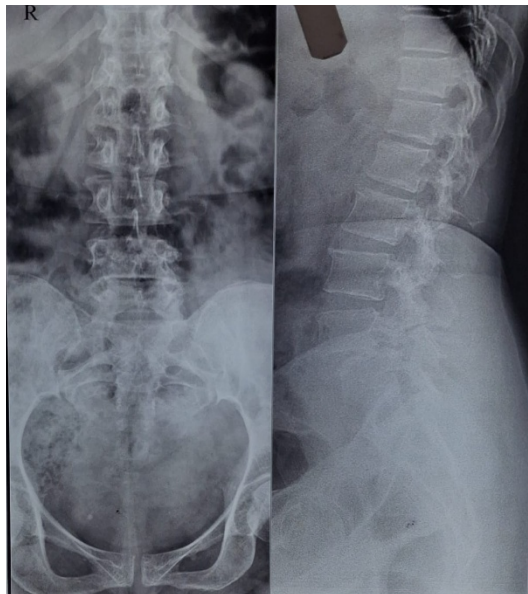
Preoperative X-ray - AP & Lateral view
